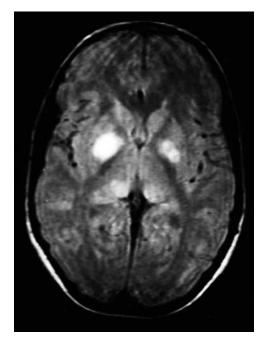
Neurofibromatosis 1 (NF-1). T₂-weighted magnetic resonance imaging (MRI) demonstrates high signal–intensity areas in the region of the globus pallidus bilaterally. (*Courtesy Division of Neuroradiology, University Health Center of Pittsburgh, Pittsburgh, Pa.*)
